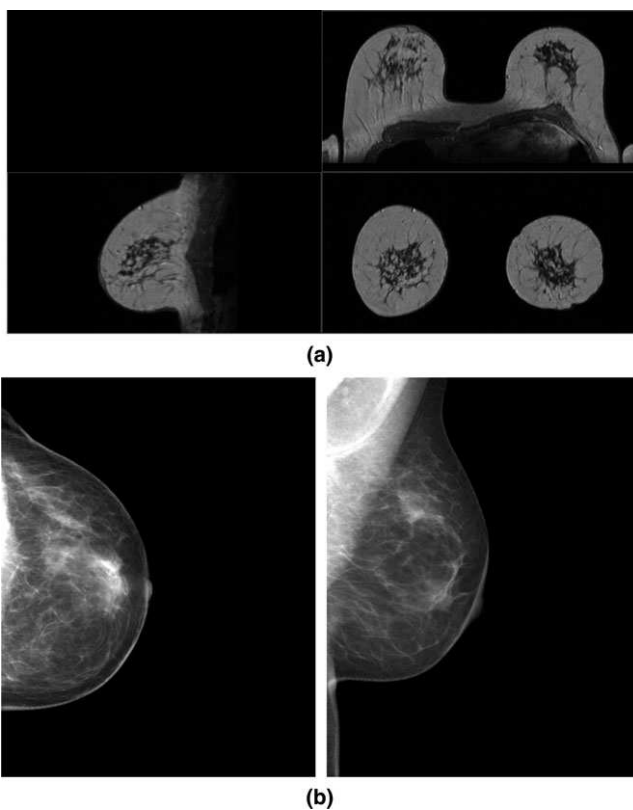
T1 precontrast MR image (a) and x-ray mammographies in cranio-caudal (CC) and mediolateral oblique (MLO) projections (b). Notice that in the MRI, the glandular tissue appears darker than the adipose, while in the x-ray mammograms, the glandular tissue is brighter.
